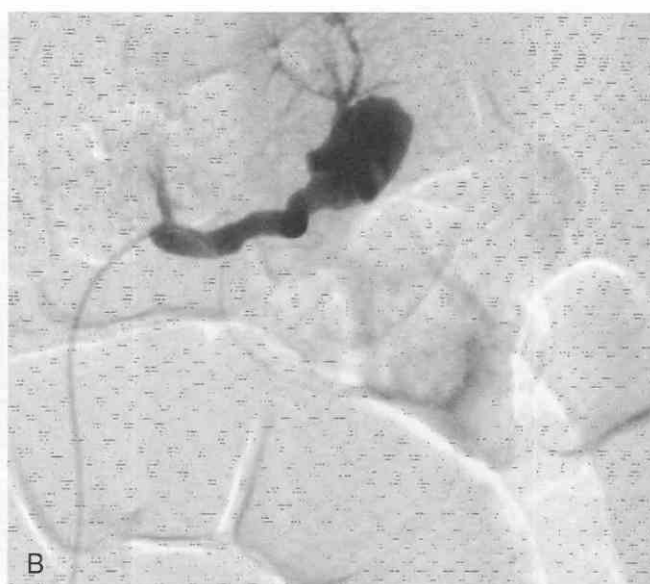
Left renal aneurysm A, Contrast-enhanced axial CT shows an extrarenal large aneurysm with thrombus (arrow) and focal calcification in its wall posteriorly. The embolus from the aneurysm has resulted in segmental infarct (large arrowhead). B, The selective angiogram of the left kidney confirms the extrarenal aneurysm of the renal artery.
